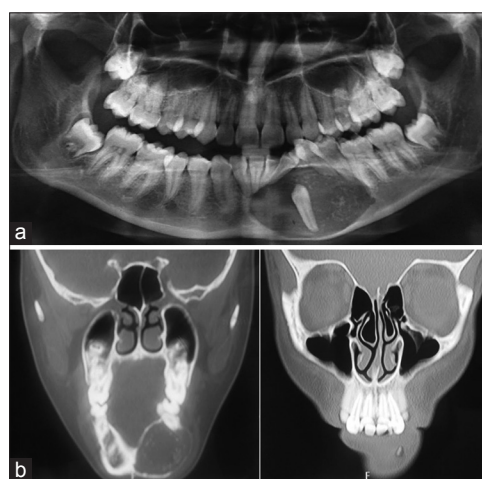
(a) Orthopantomogram of the lesion in the patient. (b) Computed tomography of the lesion in the patient.
